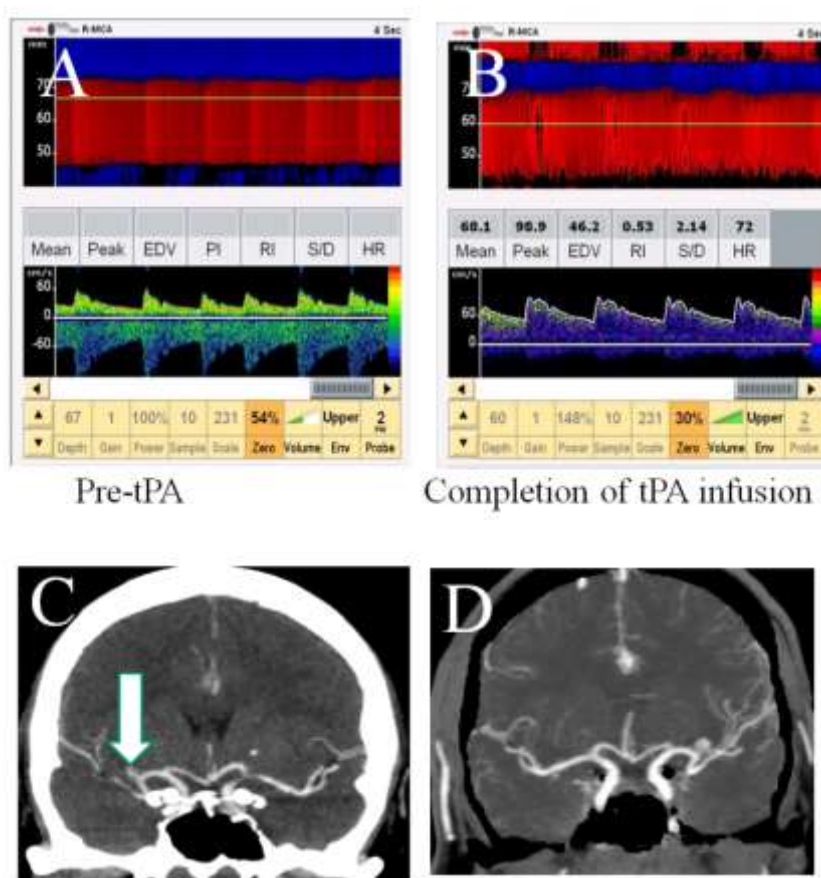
Neurovascular findings in a patient with acute right middle cerebral artery (MCA) ischemic stroke. Transcranial Doppler (TCD) performed at tissue plasminogen activator (tPA) bolus injections shows high- resistance TIBI 3 signals in right proximal MCA with flow diversion into the right ACA (A). The patient achieved complete recanalization in the form of normal flow spectra in right MCA (B) at the end of tPA infusion. This was accompanied by significant clinical improvement (NIHSS dropped from 11 to 2 points) during one hour. Brain CT angiography before tPA bolus had confirmed the occlusion of right MCA (C) that recanalized on the imaging performed on day 2 (D).
